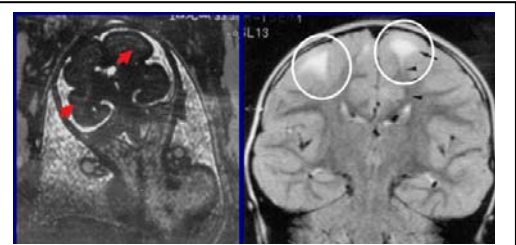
Left, Fetal brain MRI depicting two tubers at 25 weeks gestation (arrows). Right, two tubers in mature brain (circled).
